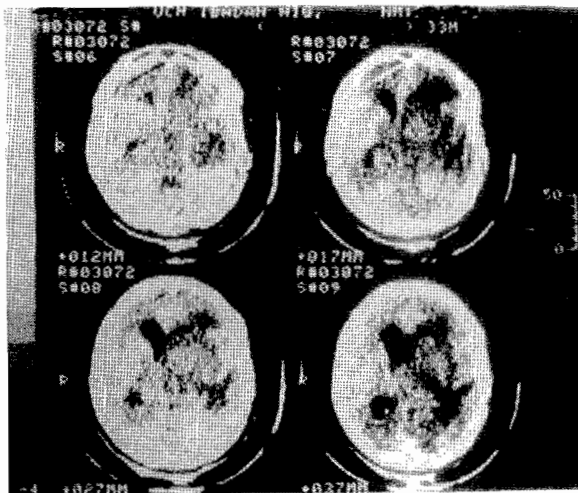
Non contrast enhanced cranial CT scan for patient 4 showing mixed density lesion in the left basal ganglia with extensive perilesional oedema and effacement of the ipsilateral lateral ventricle.
